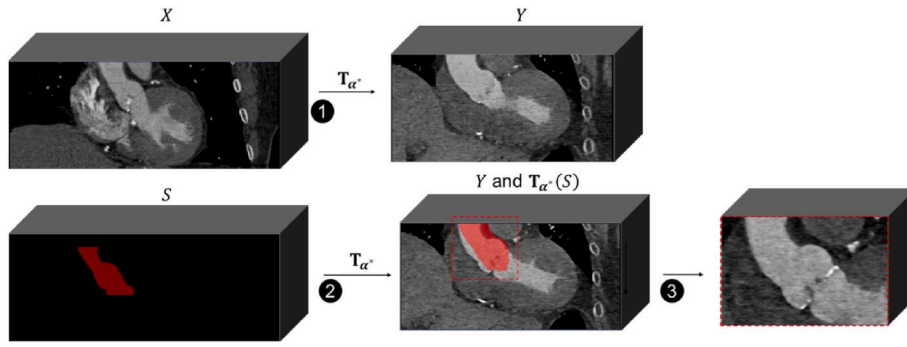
Template-matching approach for automatic identification of the region of interest (ROI) from 3D computed tomography (CT). A template image (X) for which aortic segmentation (S) is known, is affinely registered to the processed image (Y). The transformation mapping X to Y (T_{α^*}) is applied to S and the bounding box of $T_{\alpha^*}(S)$ is used to crop the ROI from Y .
